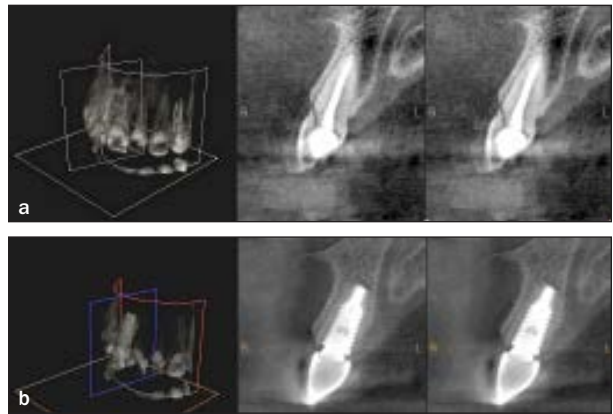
(a) Baseline and (b) 4-year follow-up CBCT cross sections showing satisfactory maintenance of the buccal plate on the facial aspect of the retained root fragment.
